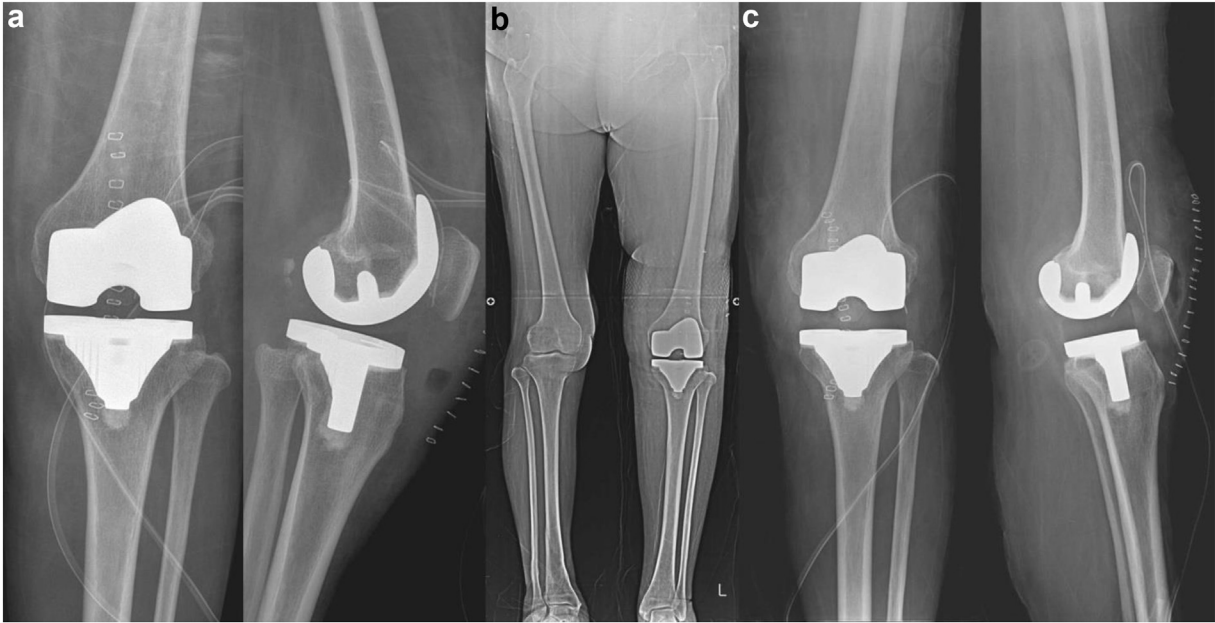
(a) Patient 1. A 63-year-old female underwent left total knee arthroplasty (TKA) with a 10-mm tibial insert. A lateral radiograph shows a femoral component flexion angle of 4.8° and a posterior tibial slope of 2.0°. (b) A postoperative standing anteroposterior (AP) radiograph shows a left hip-knee-ankle (HKA) angle of 1.9°. (c) She underwent isolated tibial insert exchange with an 18-mm tibial insert following tibial post fractures.
